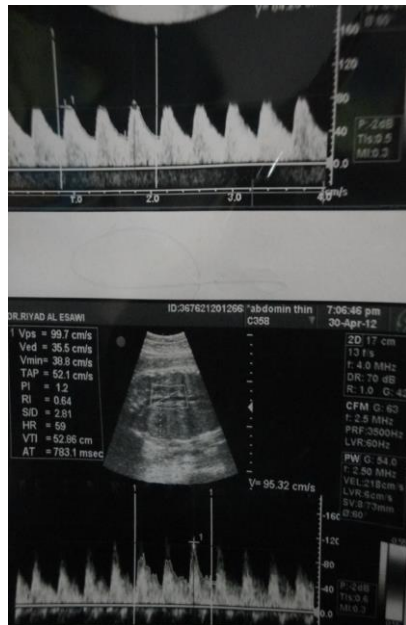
Doppler wave forms of AU (above) & Ao (below) at 36 weeks of gestation
